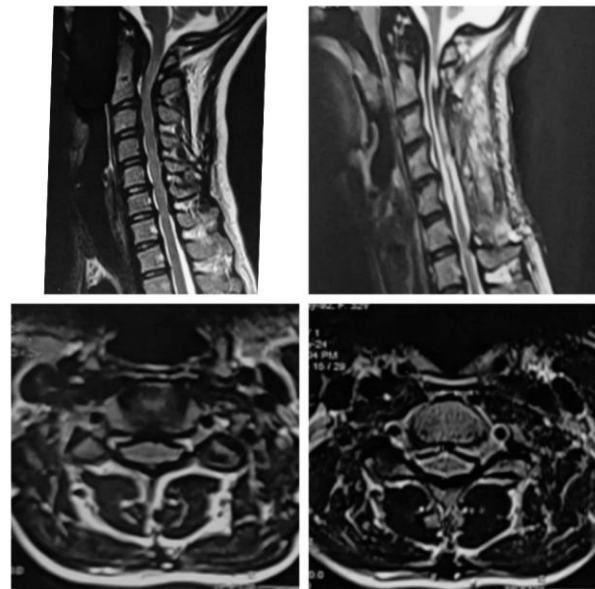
a,c; Pre-operative MRI sagittal and axial scan images of patient showing severe compression with no CSF sleeve, b,d; post operative MRI sagittal and axial cuts in the same patient with transfacet fixation with laminectomy.
